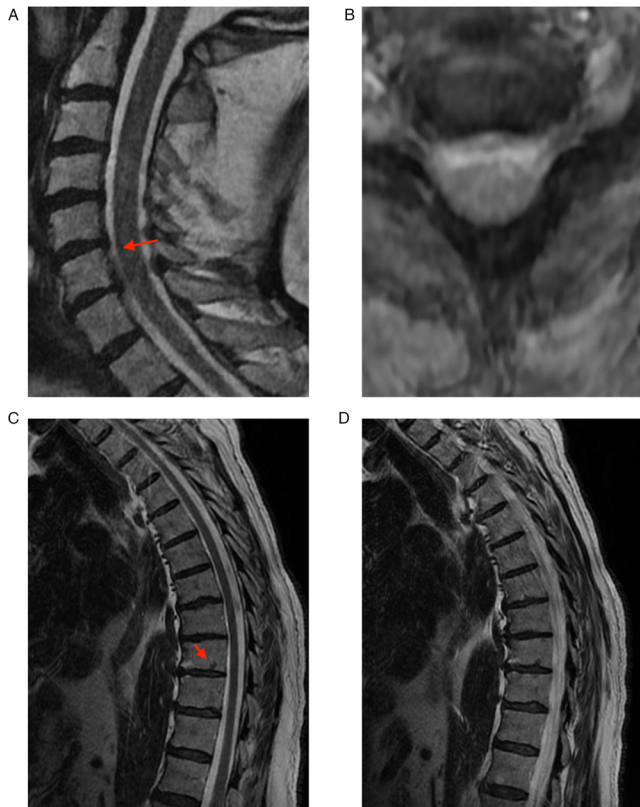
Case 1. (A) Cervical spine MRI showing herniated C5-C6 and C6-C7 disks (red arrow); (B) cervical spine MRI showing herniated C5-C6 and C6-C7 disks with discrete compression over the anterior column of cerebrospinal fluid; (C) dorsal spine MRI showing intraspongious herniations T7, T9 (red arrow); (D) dorsal spine MRI showing T10 intraspongious herniation without markings.
